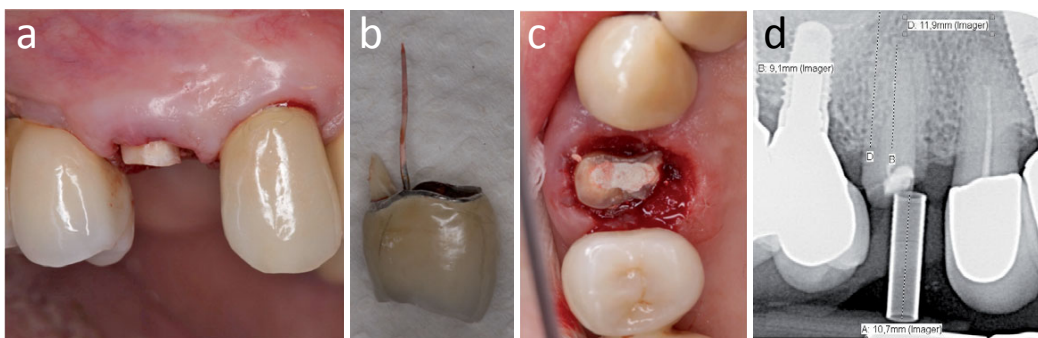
a) Fractured tooth at gingival level; b) Fractured crown with remaining tooth and guttapercha point; c) Occlusal view of remaining root in situ; root canal openings rinsed and sealed with temporary filling; d) Two-dimensional X-ray analysis for implant placement.
